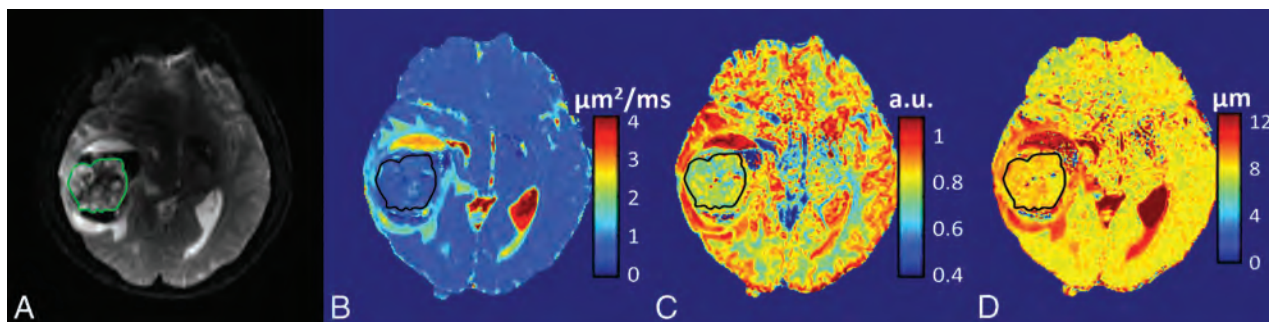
A 38-year-old male patient with a high-grade glioma (glioblastoma multiforme, WHO grade IV). T2-weighted EPI at $b=0$ with the tumor ROI encircled in green (A) and FROC parameter maps of D (B), β (C), and μ (D) with the tumor ROIs indicated by the black contours (see On-line Fig 2 for a complete set of images including axial precontrast T1-weighted FLAIR, postcontrast T1-weighted FLAIR, T2-weighted FLAIR, and T2-weighted PROPELLER images). Compared with the patient with an oligodendroglioma in Fig 1, all 3 FROC parameters exhibited lower values. a.u. indicates arbitrary units. The color scale in (B) is expressed in square micrometers/millisecond.
